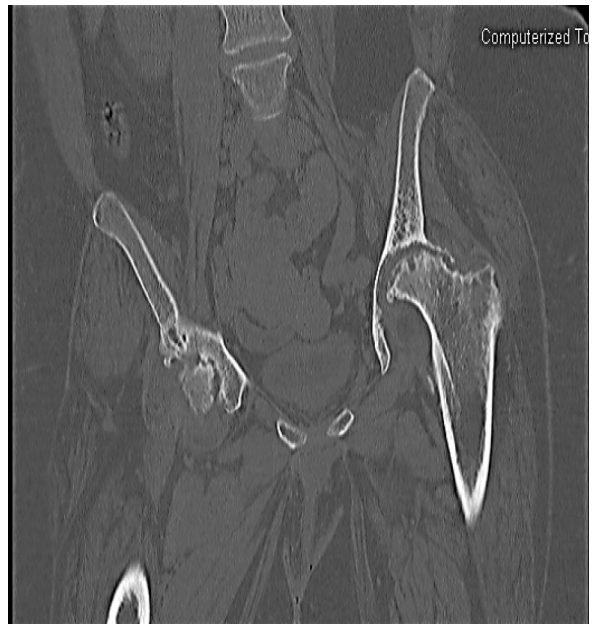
Coronal CT scan of the pelvis without contrast: advanced degenerative changes in both hip joints with partial resorption of both femoral heads worse on the left, no fracture was noted
